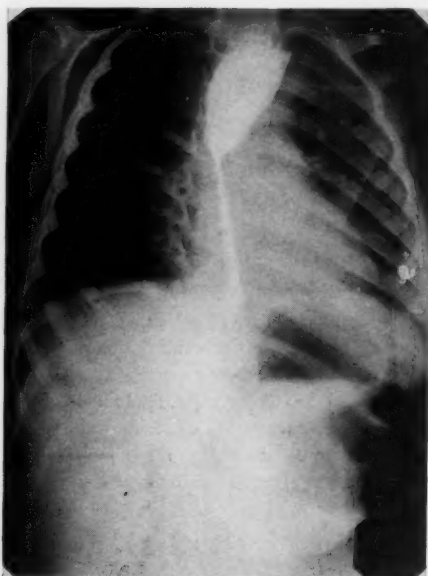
Roentgenogram taken approximately ten weeks after a lye burn, demonstrating practically a complete stricture of the lower third of the esophagus. There is considerable dilatation of the esophagus above the stricture.
